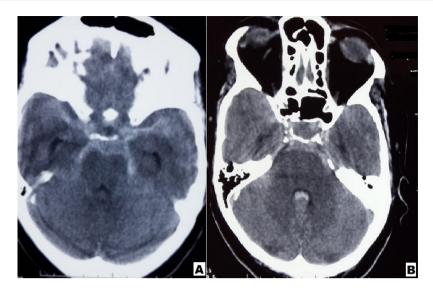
Preoperative cranial computerized tomography (CT) revealed on subarachnoid hemorrhage (SAH) that evaluated as grade 4 in Fisher scale and mild hydrocephalus. (A) Perimesencephalic SAH and mild hydrocephalus is appearing in temporal horns of lateral ventricle. (B) intraventricular hemorrhage in fourth ventricle, i.e. that is Fisher grade IV SAH.
